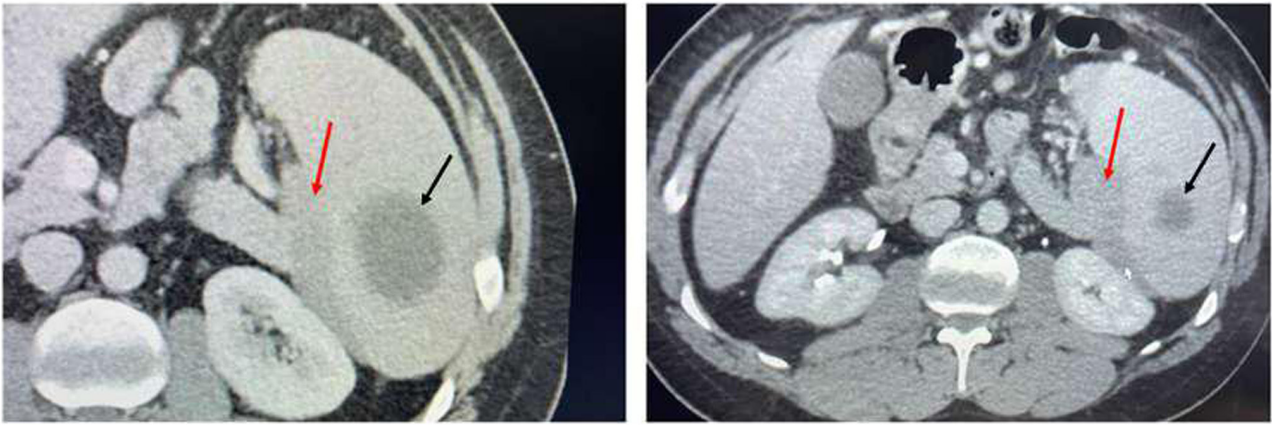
Axial contrast-enhanced abdominal computed tomography imaging findings, shows an intrasplenic cyst (black arrow) and a large low-attenuation mass in the enlarged spleen (red arrow), extending from the portal of the spleen to its inferior pole and involving the splenic vein.
